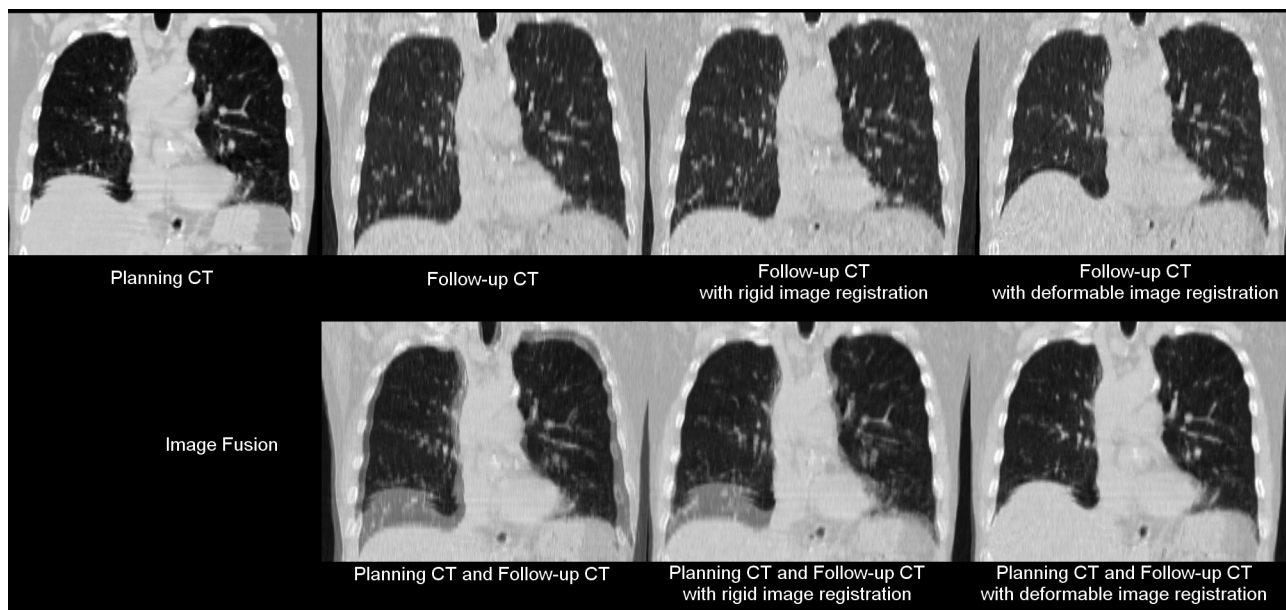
The procedure for merging follow-up CT with planning CT.
